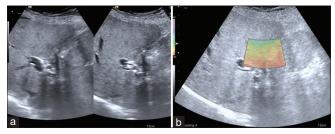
ADS class III c patient (a) Ultrasound image with contracted small gallbladder with calculus (b) E3adhesions seen on VTI image. VTI: Virtual touch imaging
